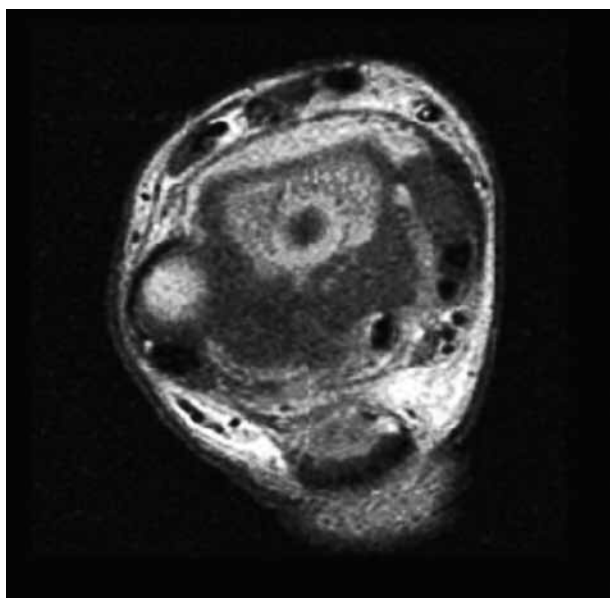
Penumbra sign of primary subacute osteomyelitis on T1-weighted axial MRI images of case 1 (patient LW) at diagnosis.
